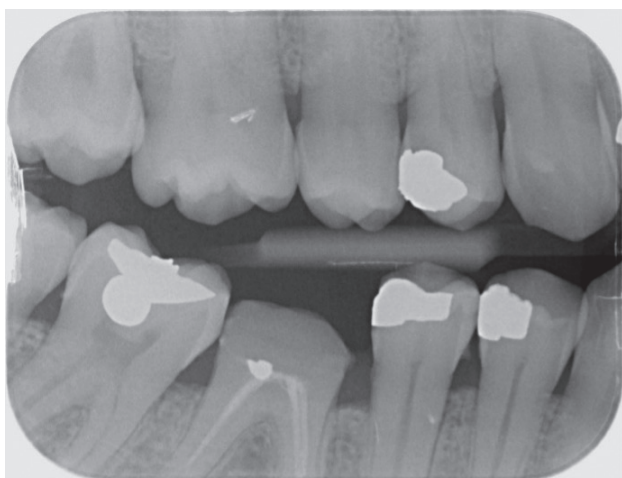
Father – X-ray Images. A. Right side. B. Left side.
